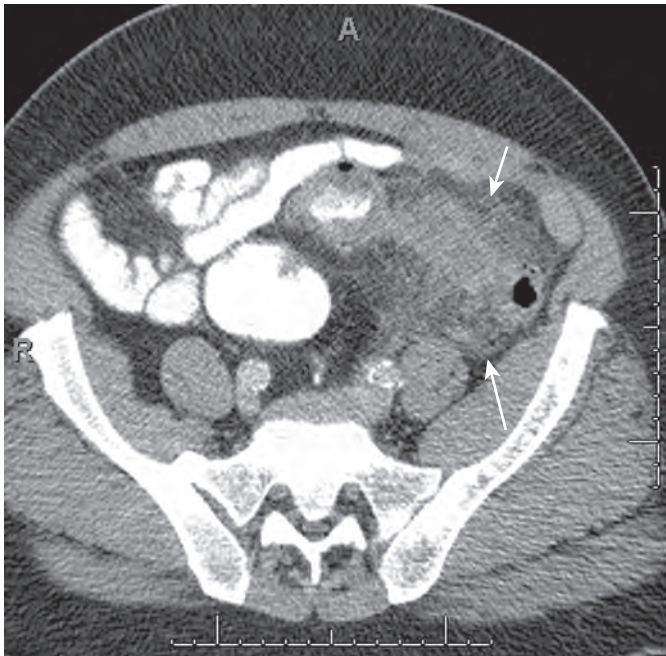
Diverticulitis. Axial CT in a patient with diverticulitis with stranding along the sigmoid colon (arrows).
